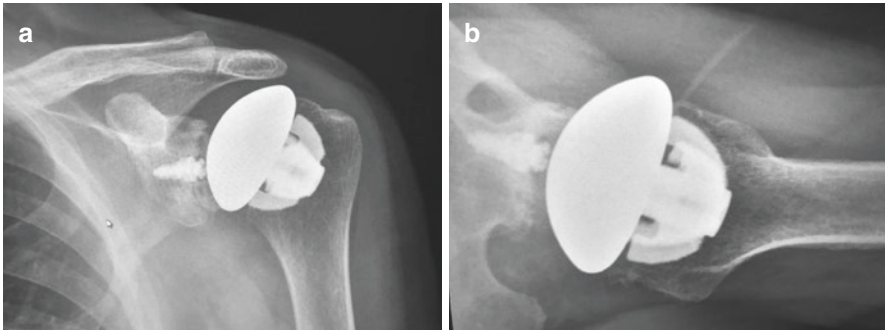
X-rays showing reverse total shoulder arthroplasty
